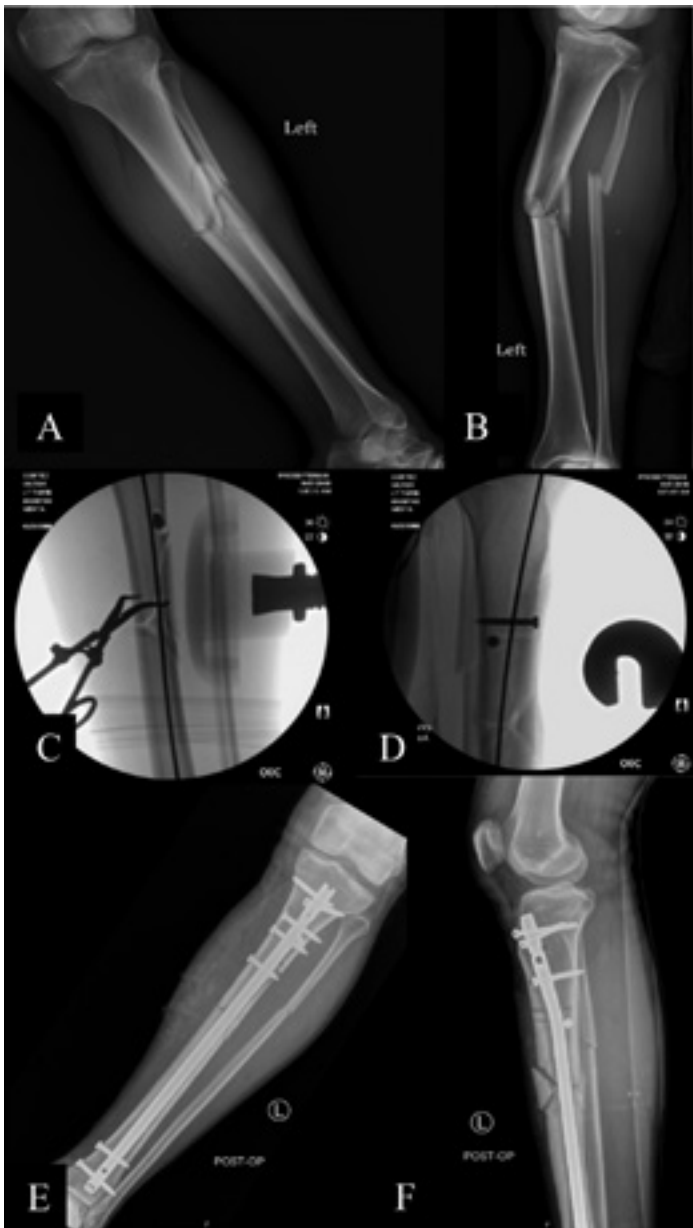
Radiographs demonstrating the use of cortical replacing screws for improving intra-operative reduction of a proximal-third tibial shaft fracture during insertion of an intramedullary nail. (A) AP radiograph of a proximal-third tibial shaft fracture with valgus mal-alignment; (B) Lateral radiograph of a proximal-third tibial shaft fracture with apex-anterior deformity; (C) Intra-operative fluoro with reduction of the fracture using clamps; (D) Intra-operative fluoro with a guidewire passing after placement of posterior and lateral cortical replacing screws; (E) Post-operative AP radiograph of a proximal-third tibial shaft fracture after intermedullary nailing using cortical replacing screws; (F) Post-operative lateral radiograph of a proximal-third tibial shaft fracture after intermedullary nailing using cortical replacing screws.
